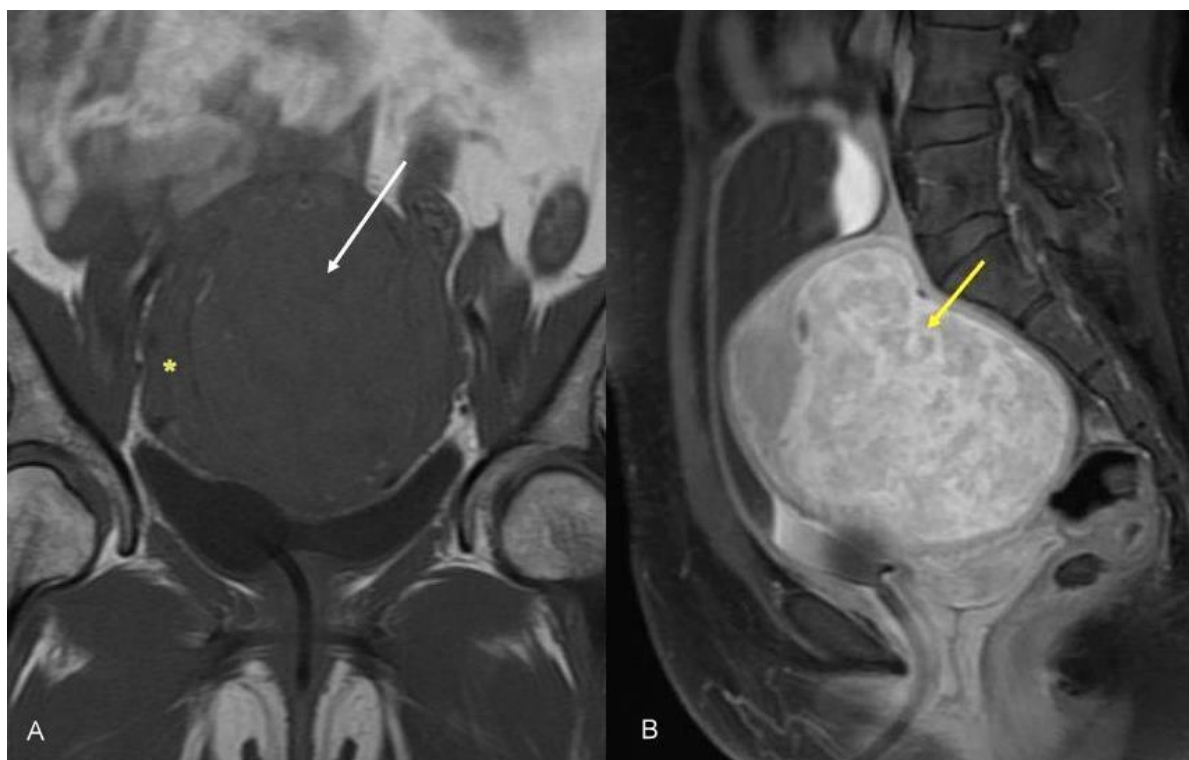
44 year old nulliparous woman with intramural fibroid and acute retention of urine. A: T1WI coronal screening MR of the pelvis shows the fibroid (white arrow) isointense relative to the uterine wall (asterix). B: Contrast enhanced SPGR sagittal screening MR of the pelvis shows enhancement of the fibroid (yellow arrow). (Protocol- A: 1.5T MRI, TR: 720ms, TE: 13.2ms) (Protocol- B: 1.5T MRI, TR: 900ms, TE: 13.2ms, 10ml gadodiamide USP [Omniscan])
